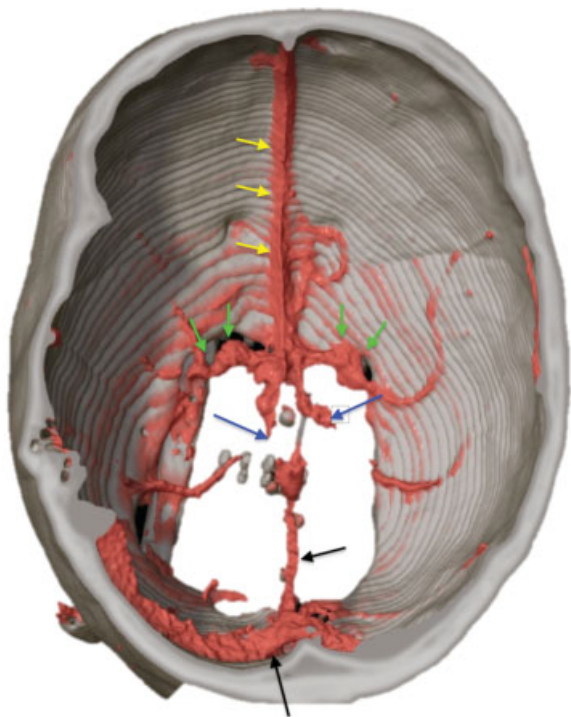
Three-dimensional reconstruction of venous phase CT angiography (performed 12 hours post OP). The rostral segment of the superior sagittal sinus is intact (yellow arrows). Flow void of the severed sinus segment (blue arrows). Dilated bridging veins as part of the collateral circulation (green arrows). Additional collateral veins feeding the transverse and rectus sinus (black arrows). CT, computed tomography; OP, operation.
